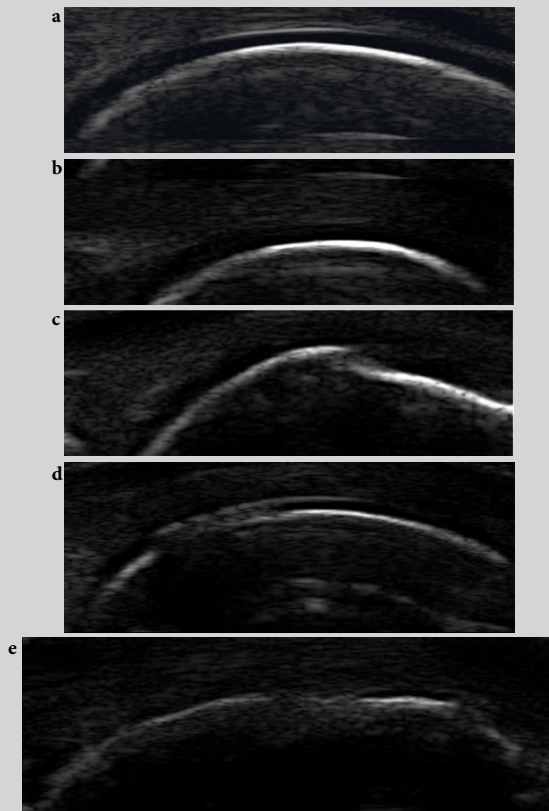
Ultrasound findings of cartilage involvement in a longitudinal dorsal scan of metacarpophalangeal joint. (a) Normal aspect; (b) heterogeneous echotexture and/or loss of sharpness; (c) blurring of anterior or posterior interface; (d) asymmetric thinning; (e) complete loss of cartilage.
